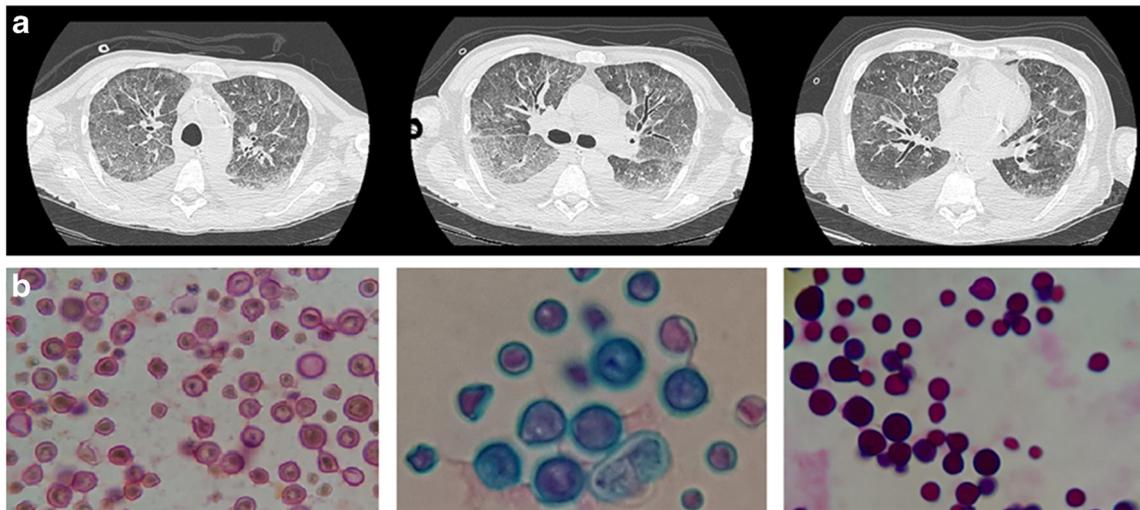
a Computed tomography scan showing interlobular septal thickening, focal alveolar consolidation and diffuse ground-glass opacities, mediastinal lymphadenopathy, and bilateral pleural effusion. b
